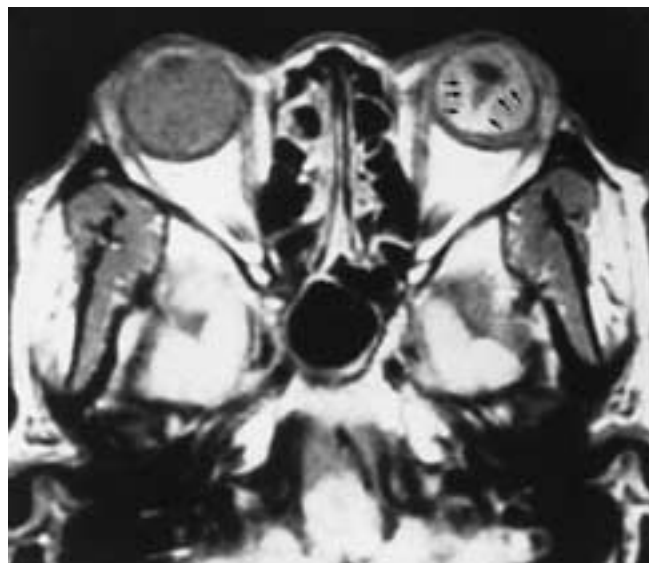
Serous choroidal detachment. Axial PW MR image shows a kissing choroidal detachment. Suprachoroidal fluid is slightly hyperintense compared with that of the normal right vitreous. The detached choroid (arrows) appears thick, and its hyperintensity is caused by accumulation of fluid in its interstitium.
